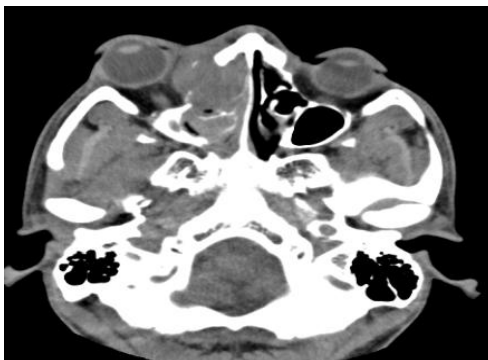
plain CT show homogenous extraconal mass involving right orbit .
